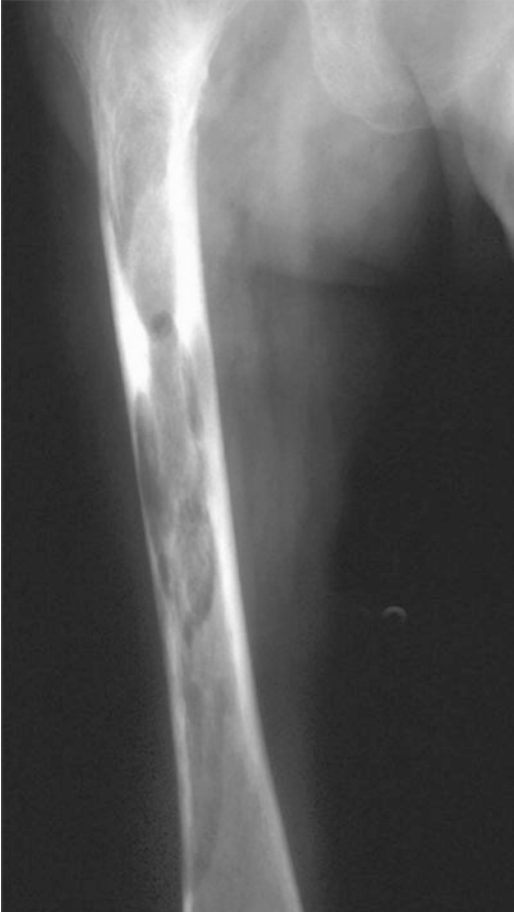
Radiograph of a femur bone affected with Paget's disease demonstrating the typical osteolytic pattern (flame-shaped) of the disease
